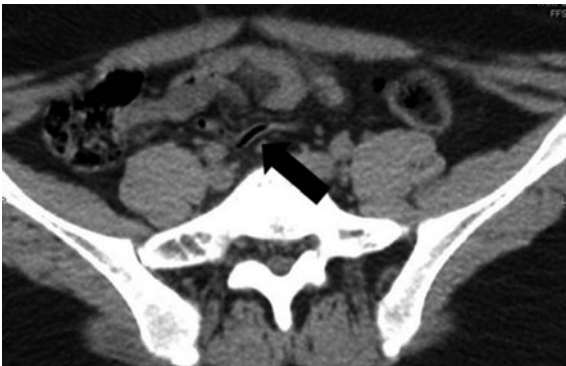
Normal appendix in a 14-year-old-female. Axial contrast-enhanced CT identifies the normal appendix (*arrow*). Note presence of intraluminal air without appendiceal thickening or periappendiceal inflammation
